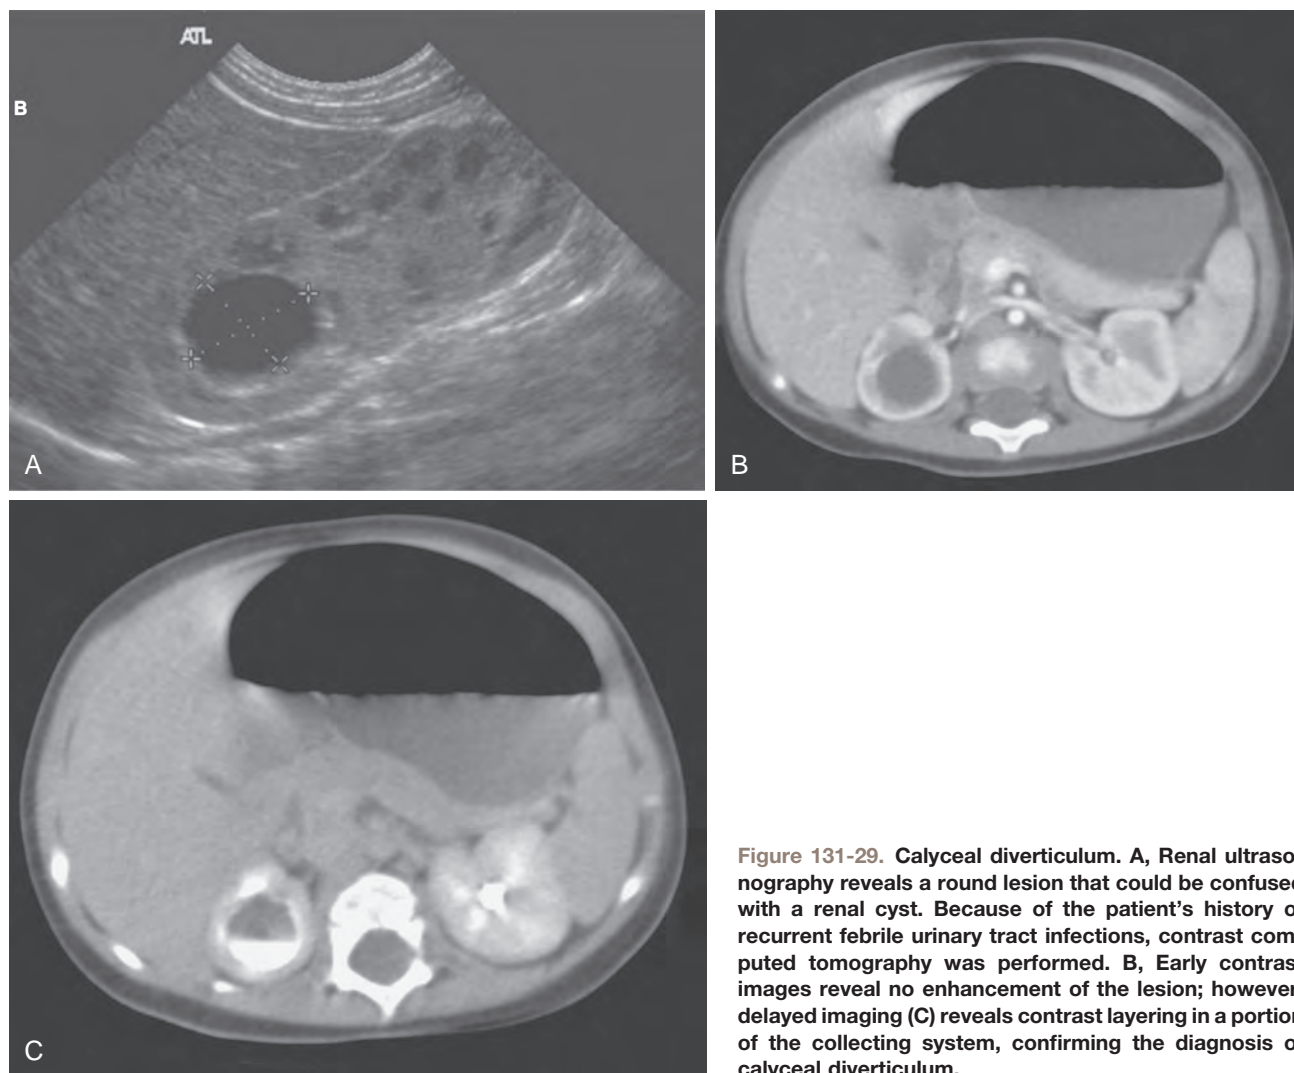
Calyceal diverticulum. A, Renal ultrasonography reveals a round lesion that could be confused with a renal cyst. Because of the patient's history of recurrent febrile urinary tract infections, contrast computed tomography was performed. B, Early contrast images reveal no enhancement of the lesion; however, delayed imaging (C) reveals contrast layering in a portion of the collecting system, confirming the diagnosis of calyceal diverticulum.
